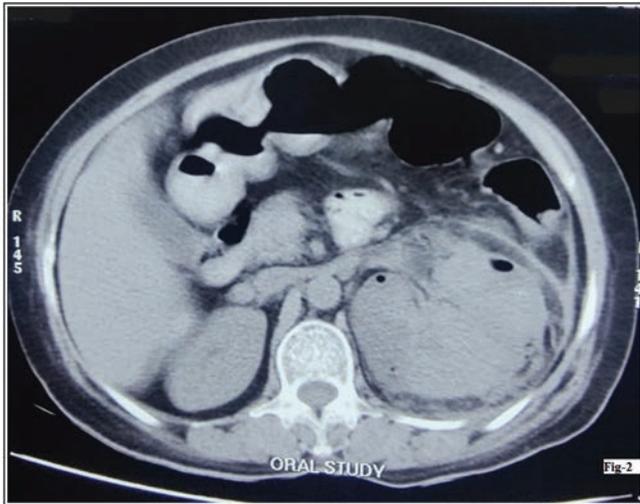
Class 2 EPN on CT scan showing gas in the left renal parenchyma
